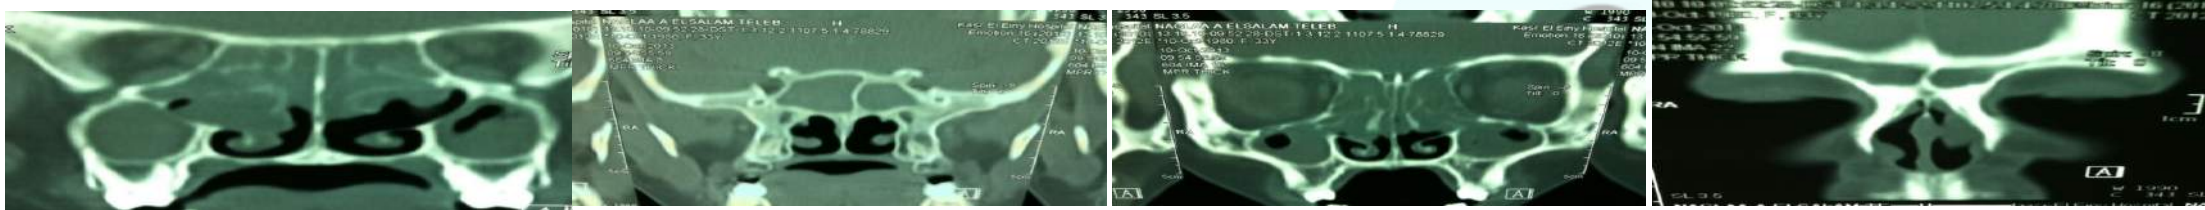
CT Nose, Paranasal Sinuses, coronal cut, bone window of sinonasal polyposis. Lund- Mackay score (22).
